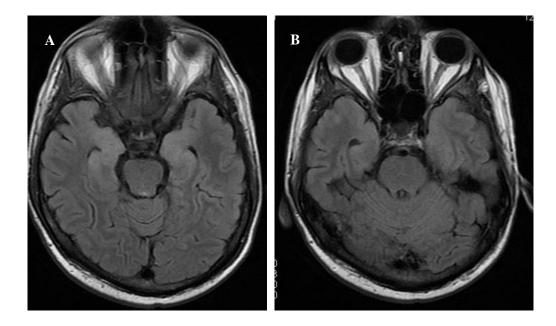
Magnetic resonance imaging (MRI) of the brain on 19th post-transplant day: fluid attenuated inversion recovery (FLAIR) showing bilateral encephalitis in the temporal lobe, mainly in the region of the hippocampus (A). Diffusion weighted images with signal hyperintensities (B).
